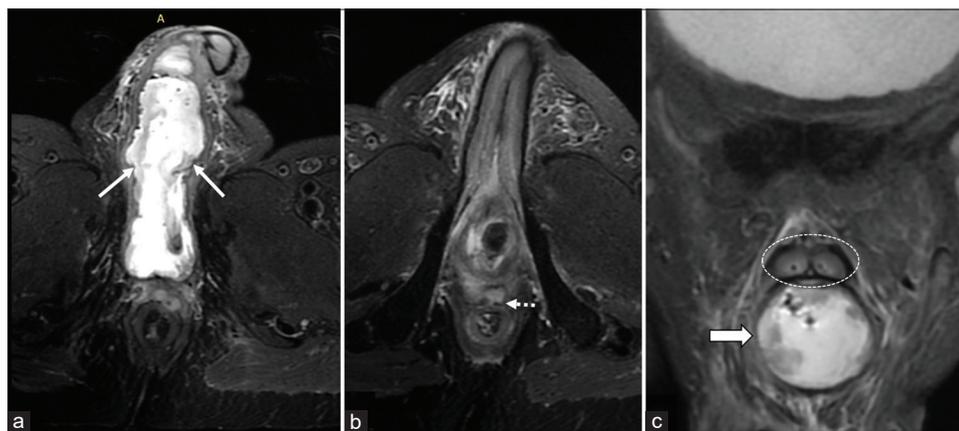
(a) Axial T2-fat saturated magnetic resonance imaging (MRI) image showing T2 hyperintense abscess (arrows) replacing the entire penile shaft (b) axial T2 MRI image showing perianal fistula at 12 o'clock position along external sphincter (dashed arrow) (c) Coronal T2 Fat suppressed image showing the abscess confined to corpora spongiosum (arrowhead) and normal corpora cavernosa (circle).
